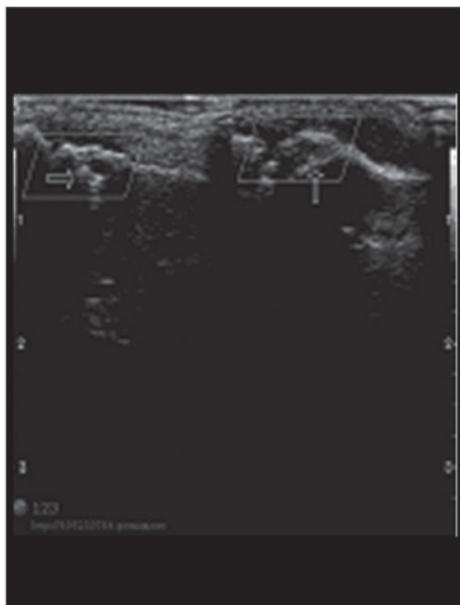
The high-frequency color Doppler ultrasonography manifestation of articulationes interphalangeae of digitus medius of the patients with bone erosion.
